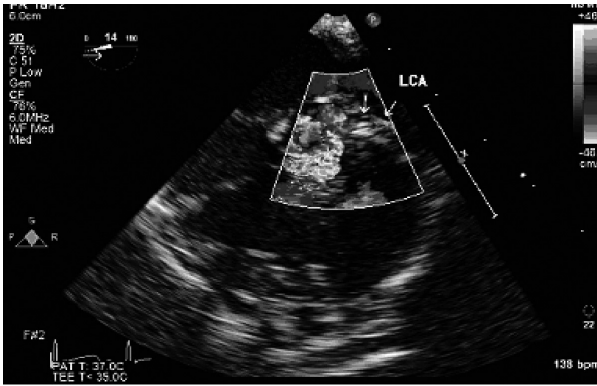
Color Doppler flow in Left Coronary Artery in a multiplane angle 14°
